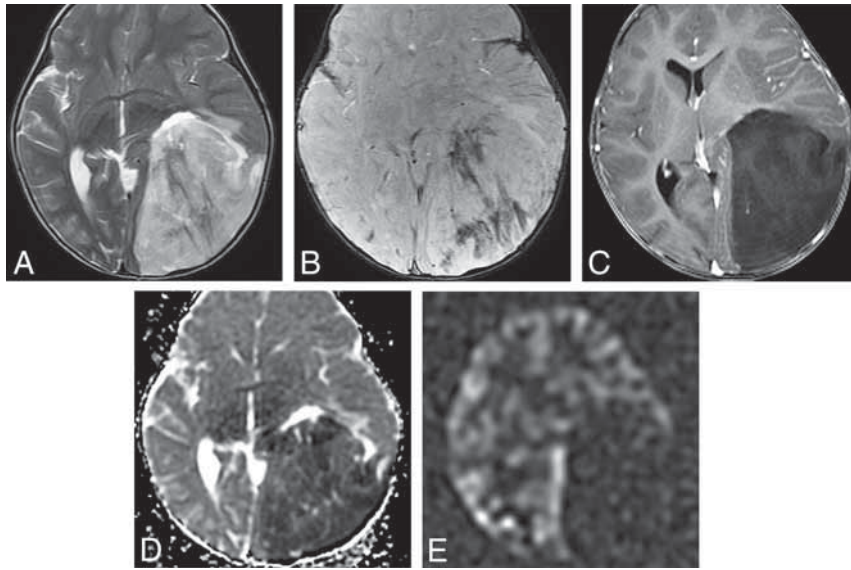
Embryonal tumor with multilayered rosettes in a 1-year-old girl. *A*, An axial T2-weighted scan shows a large, left parieto-occipital mass with little surrounding edema. *B*, The mass exhibits hemorrhage on susceptibility-weighted imaging and no enhancement following contrast administration (*C*). *D*, Strikingly restricted diffusion is seen on the ADC map. *E*, Arterial spin-labeling perfusion shows decreased perfusion in the tumor.
